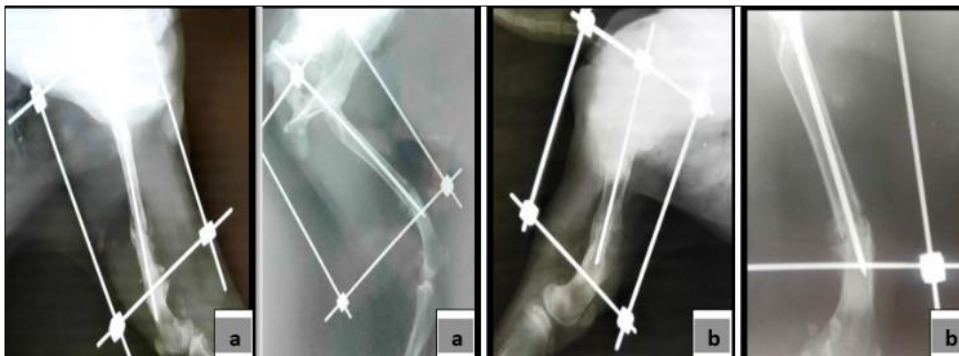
a) 4th week b) 8th week medio-lateral radiographs showing sequence of fracture healing
